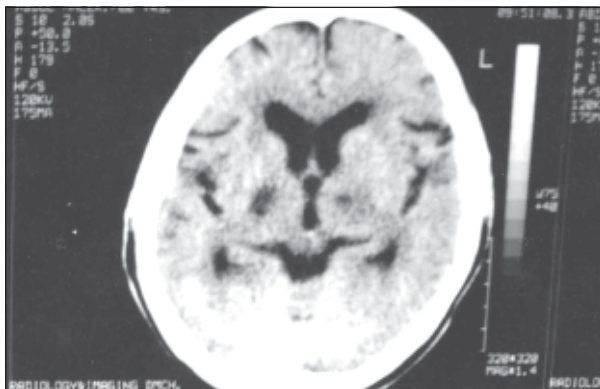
CT-Scan of brain showing small infarcts involving posterior limb of right internal capsule and left thalamus.
